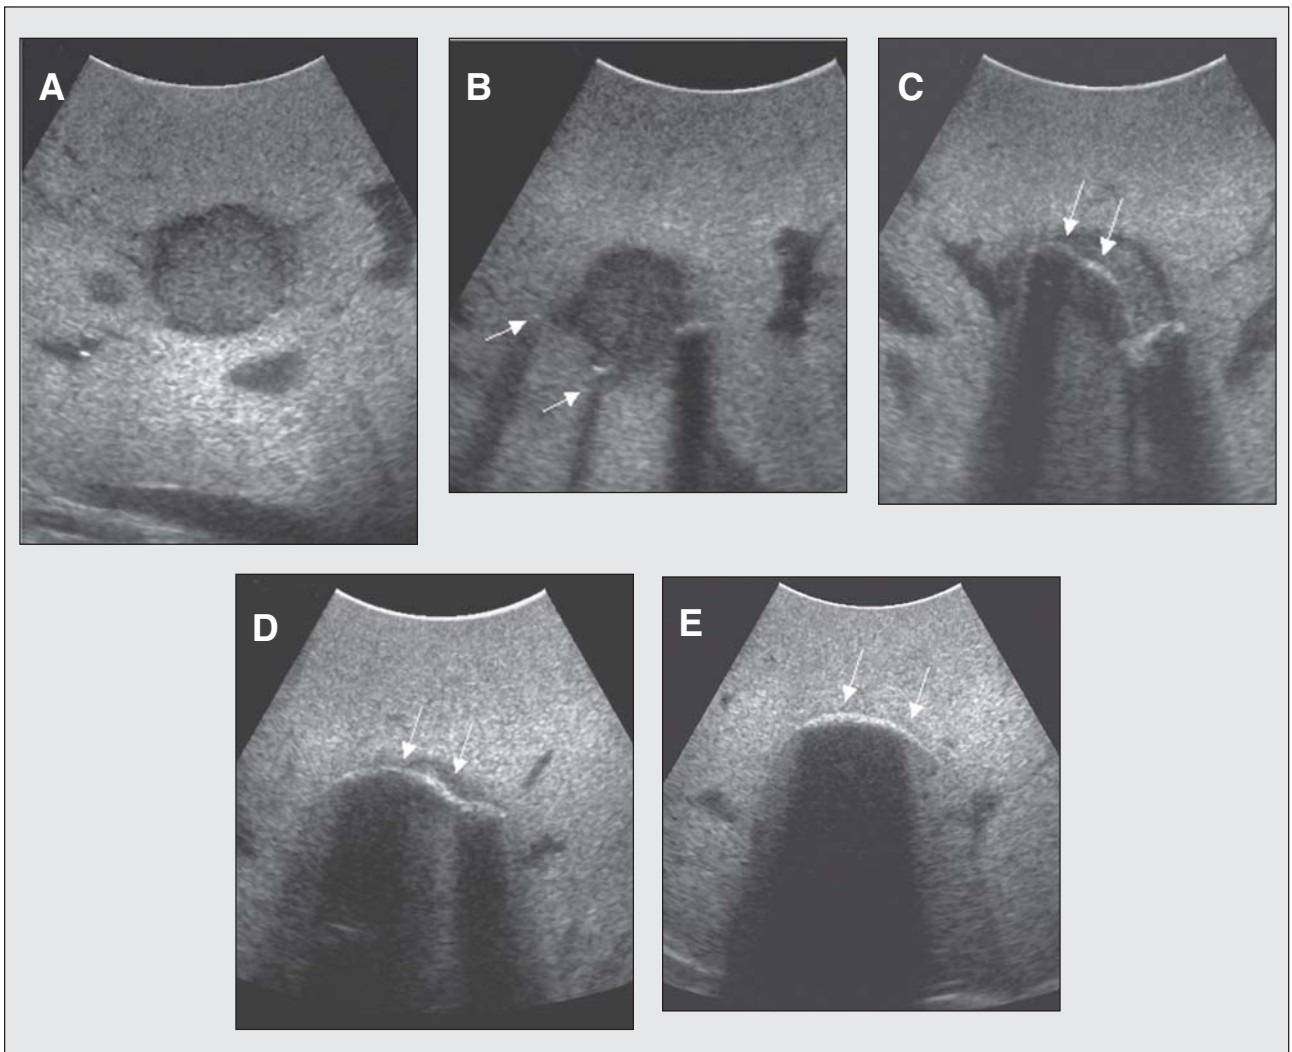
Tumor Visualization and Iceball Formation—(A) Small liver tumor is seen with intraoperative ultrasound. (B) After probe placement (arrows represent probes), two cryolesions growing from the two separate probes can be seen as hyperechoic foci (arrows in parts C, D, and E). When the iceballs fuse (E), a single conglomerate iceball completely obscures the tumor.
